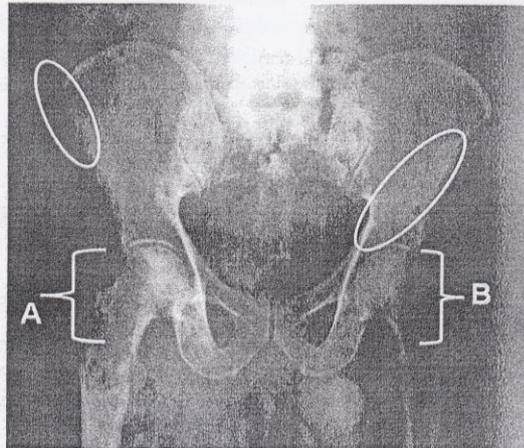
X-ray of the pelvis (antero-posterior view): multiple lytic lesion at the head of the femur bones (labelled as A and B). The white oval encircled area show multiple small lytic lesion on both pelvic bones.
